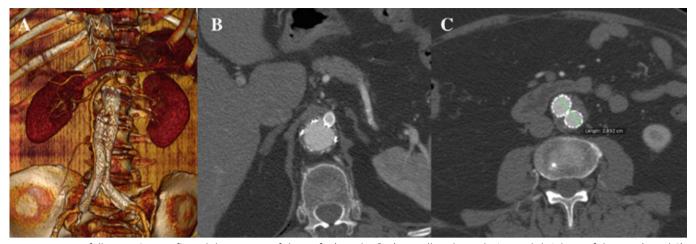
5-year follow-up CTA confirmed the patency of the grafts (Panel A & B) as well as the exclusion and shrinkage of the sacs (Panel C).
